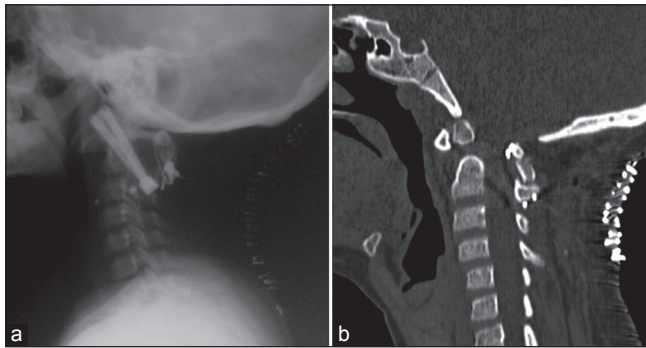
Postop radiology.(a) Lateral X-ray showing the construct. (b) The sagittal reconstruction of the CT scan showing reduction of the atlantoaxial dislocation and an adequately roomy canal
